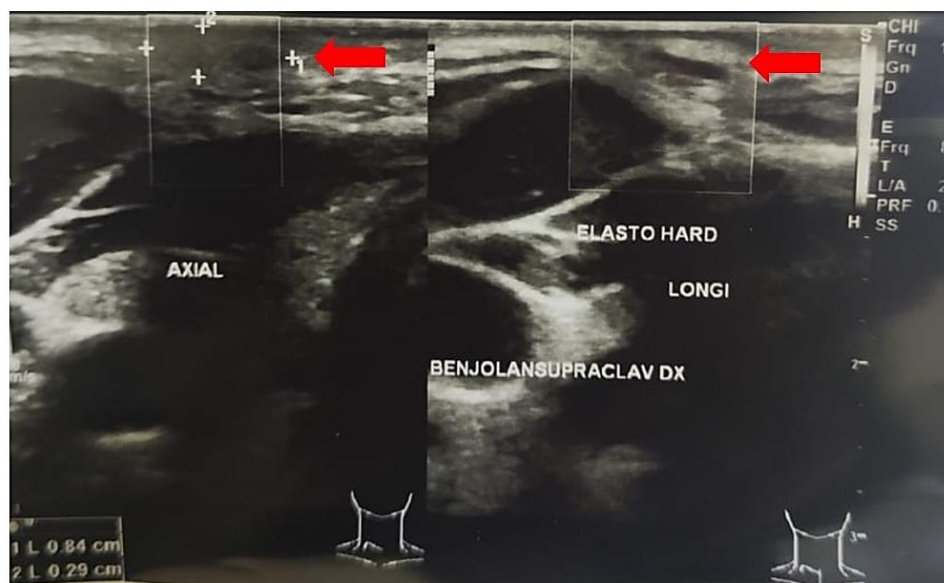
Ultrasonography showed a slightly hyperechoic ovoid, well-demarcated, and regular mass (red arrow)
